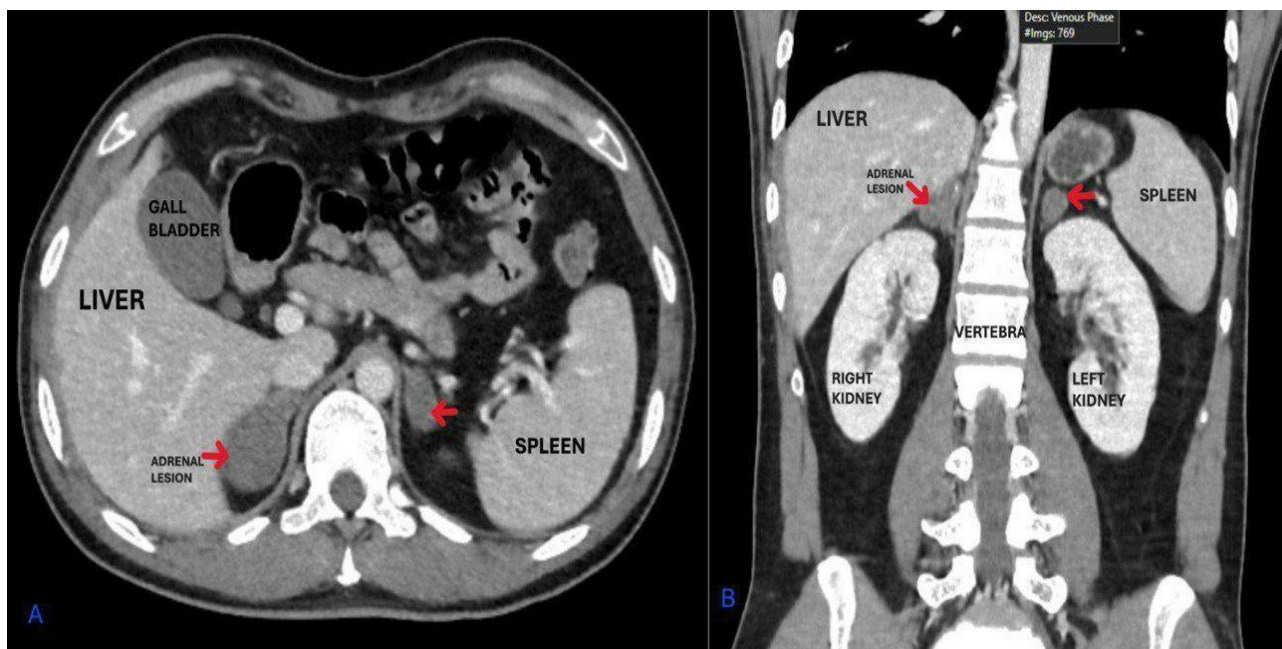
CT images highlighting adrenal gland enlargement. A) Axial CT shows bilateral adrenal glands appearing bulky (Right > Left). B) Coronal CT of the adrenal glands.
